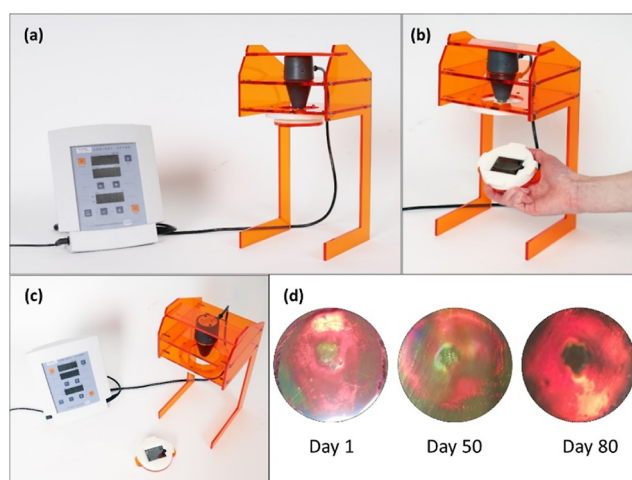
(a–c) Photographs of the prototype ultrasound testing unit. (d) Photographs of three identical holograms tested in the prototype unit 1, 50, and 80 days after their fabrication ($t = 60 \text{ s}$; power density = 5 W/m^2 ; duty cycle = 85%).
